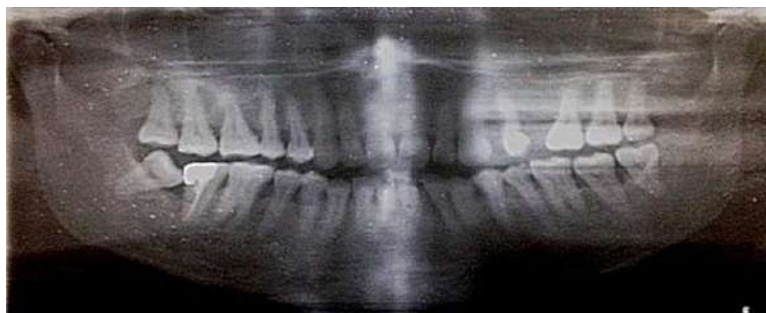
Post-treatment orthopantomogram showing appreciable bone fill in angular defects
